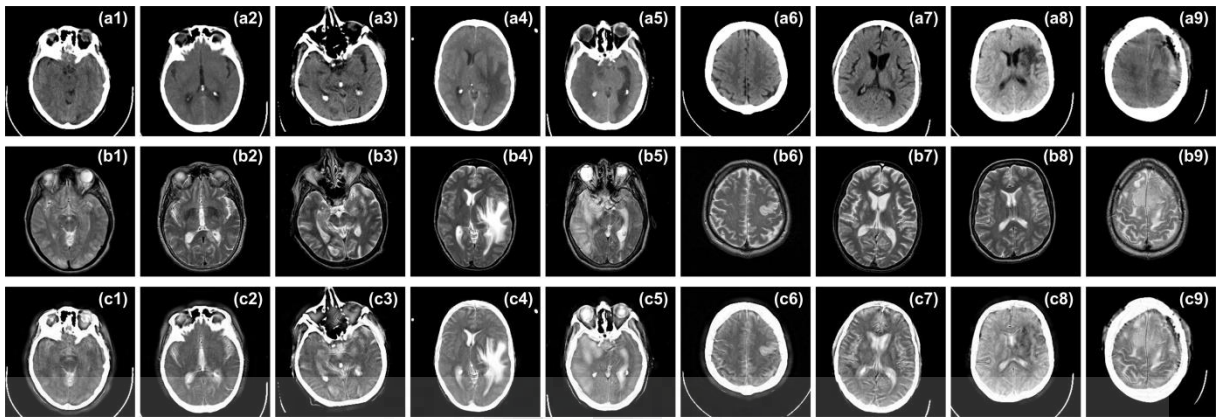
(a) Source CT images (b) Source MR images (c) Fused images obtained by the DRT-MIF approach
